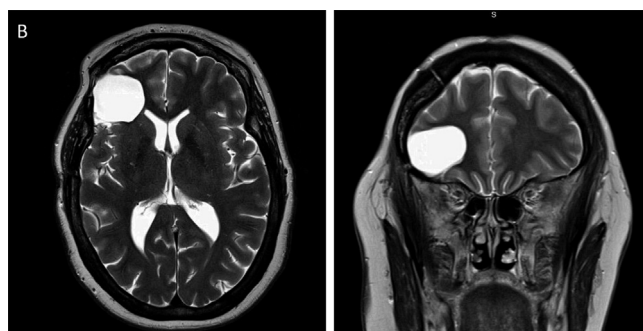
Post-Op MRI (A) Axial and Coronal FSE T2 W).
